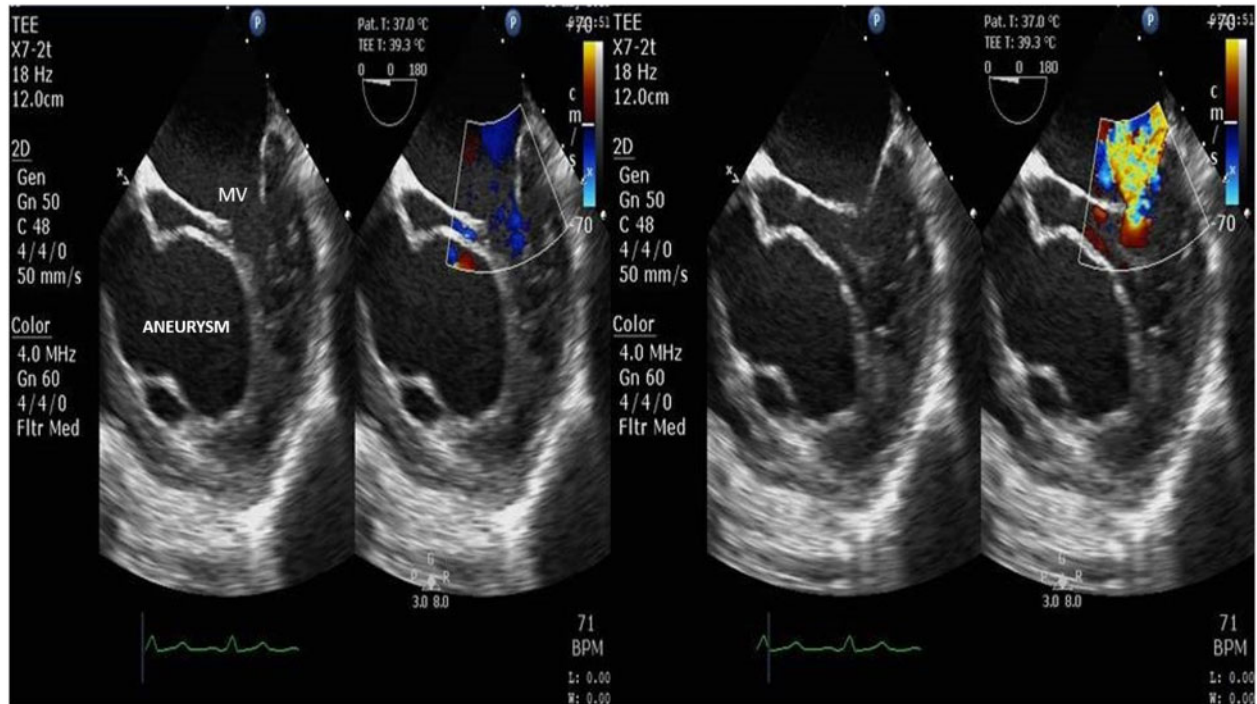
Transoesophageal echocardiography mid oesophageal level 0° view shows aneurysm sac and mitral regurgitation in the systolic frame. MV, mitral valve.
